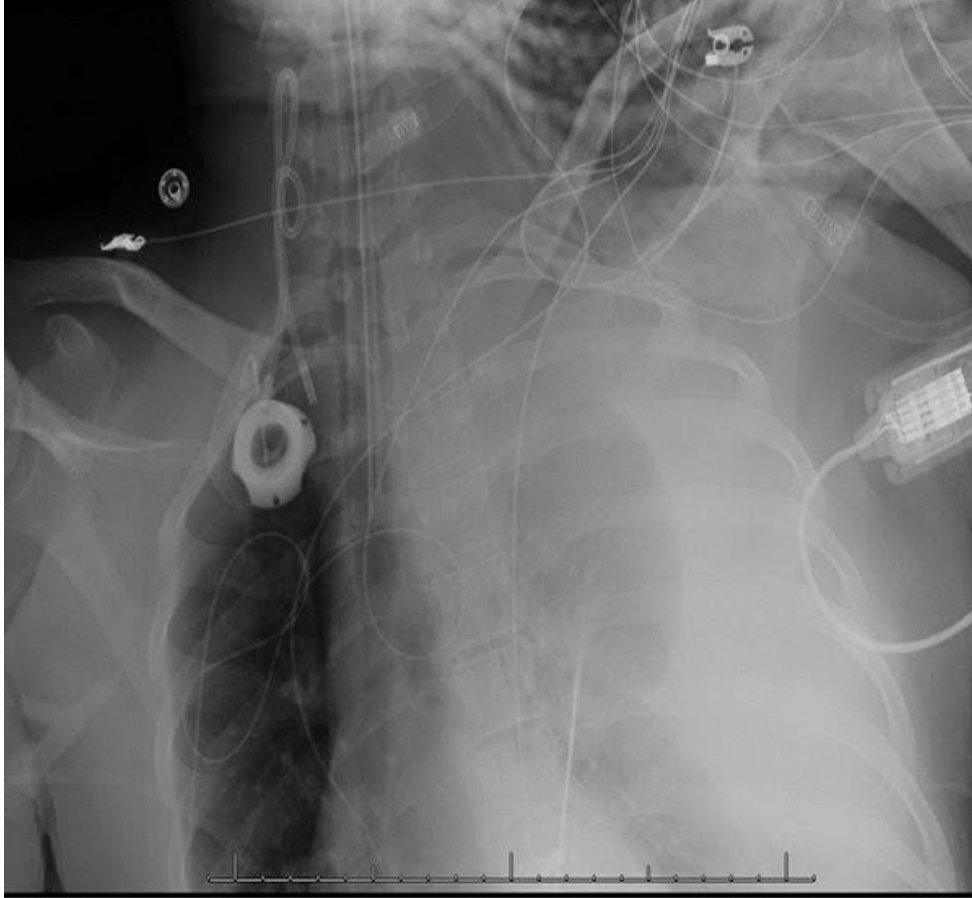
Chest X-ray after removal of CVL
